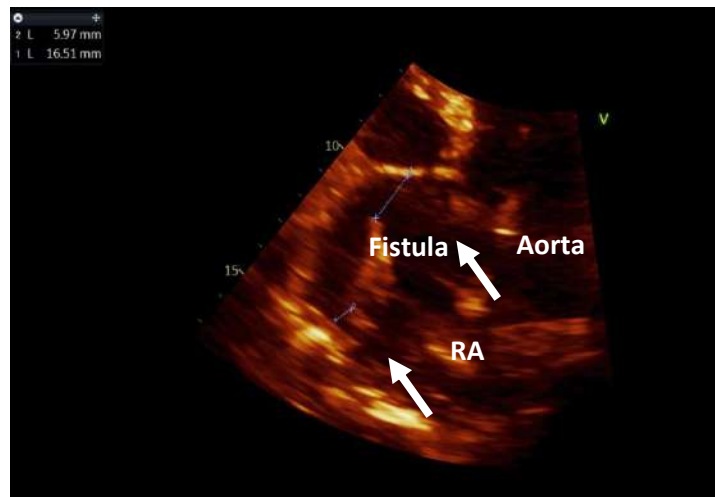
Transthoracic echo (3,4) showed large channel communicating dilated right coronary sinus to right atrium (RA).
